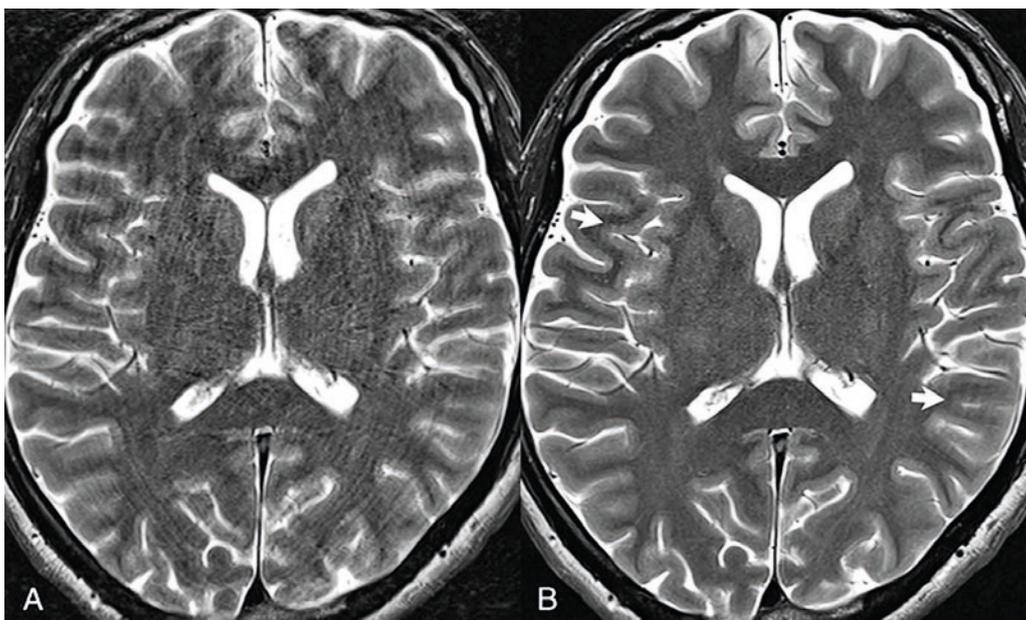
Image degradation (ghosting, blurring, loss of grey-white matter differentiation) due to mild motion in a normal volunteer, on (A) high-resolution T2-weighted fast spin echo imaging, with a marked improvement (B) using the kinetic sensor. Note the minimal residual ghosting (small white arrows) in the motion corrected image, superficial to the right insula and overlying the left parietal lobe.
